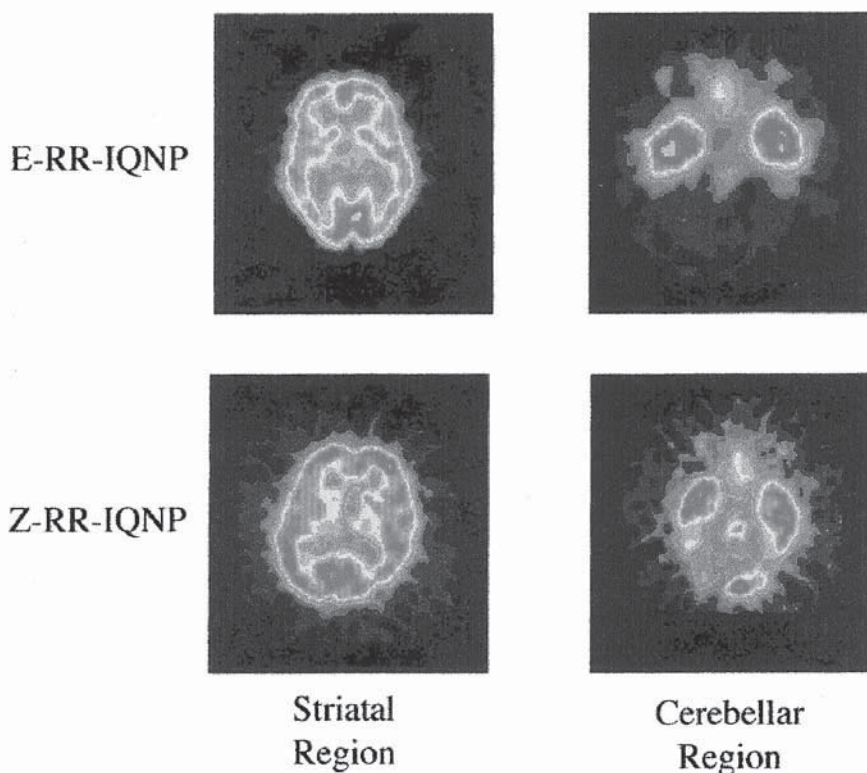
Initial human volunteer SPECT imaging study utilizing I-123-E- and Z-RR-IQNP (100 MBq) at 30 h postinjection. (Used with permission of Nobuhara, Halldin et al., Karolinska Institute, Stockholm, Sweden.)
